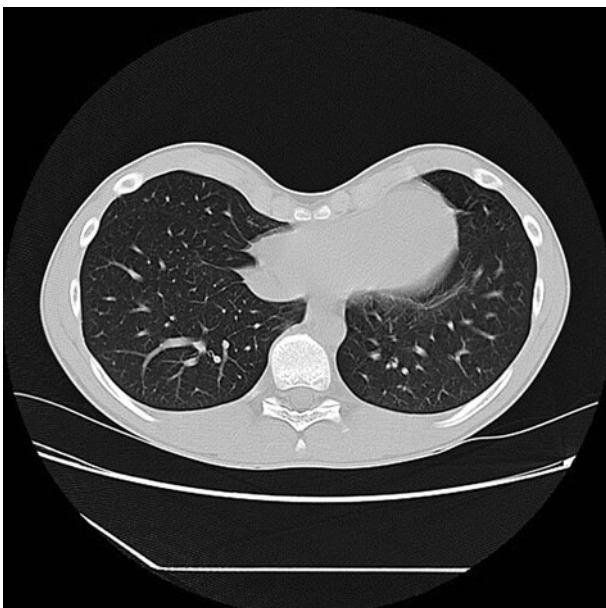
CT scan of a funnel chest patient without vacuum bell
